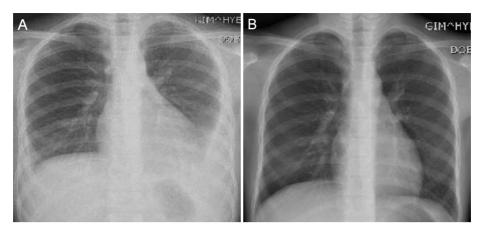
(A) Initial chest radiograph shows bilateral pleural effusions and left lower lobe consolidation in Case 2. (B) After 4 months, follow up chest radiograph shows resolution of previous lesions.
